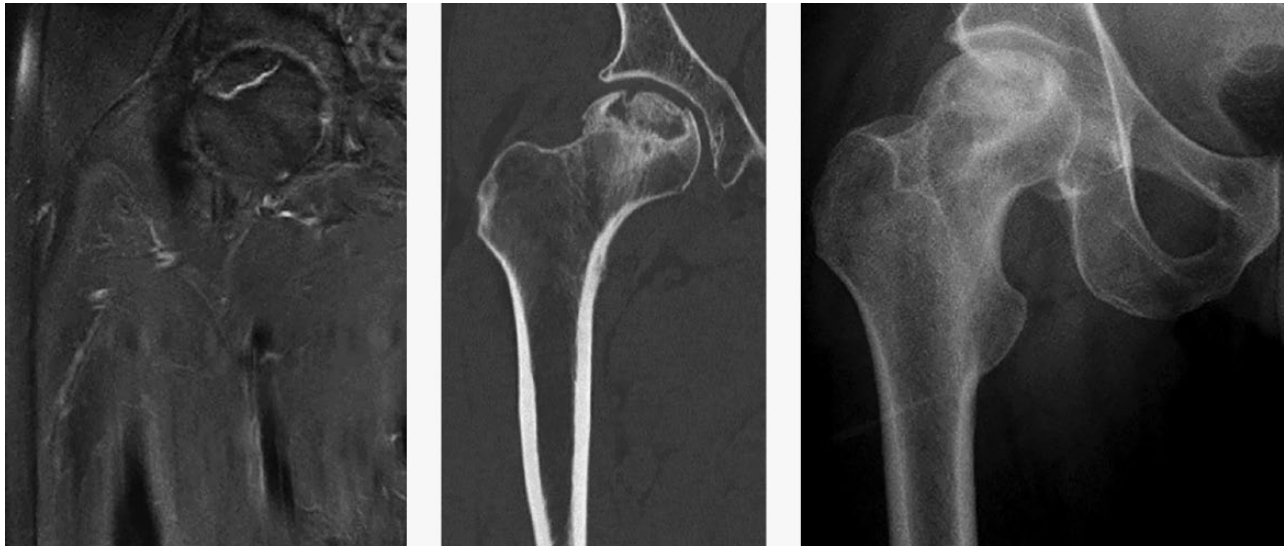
Crescent sign on a) MRI T2, b) CT scan c) radiograph.
